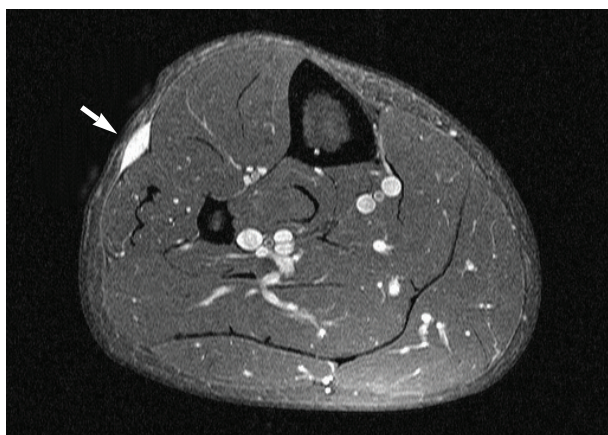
Magnetic resonance image. Axial T1-weighted image with fat saturation shows contrast enhanced, high signal intensity (arrow) in the subcutaneous tissue of the right lower leg.
